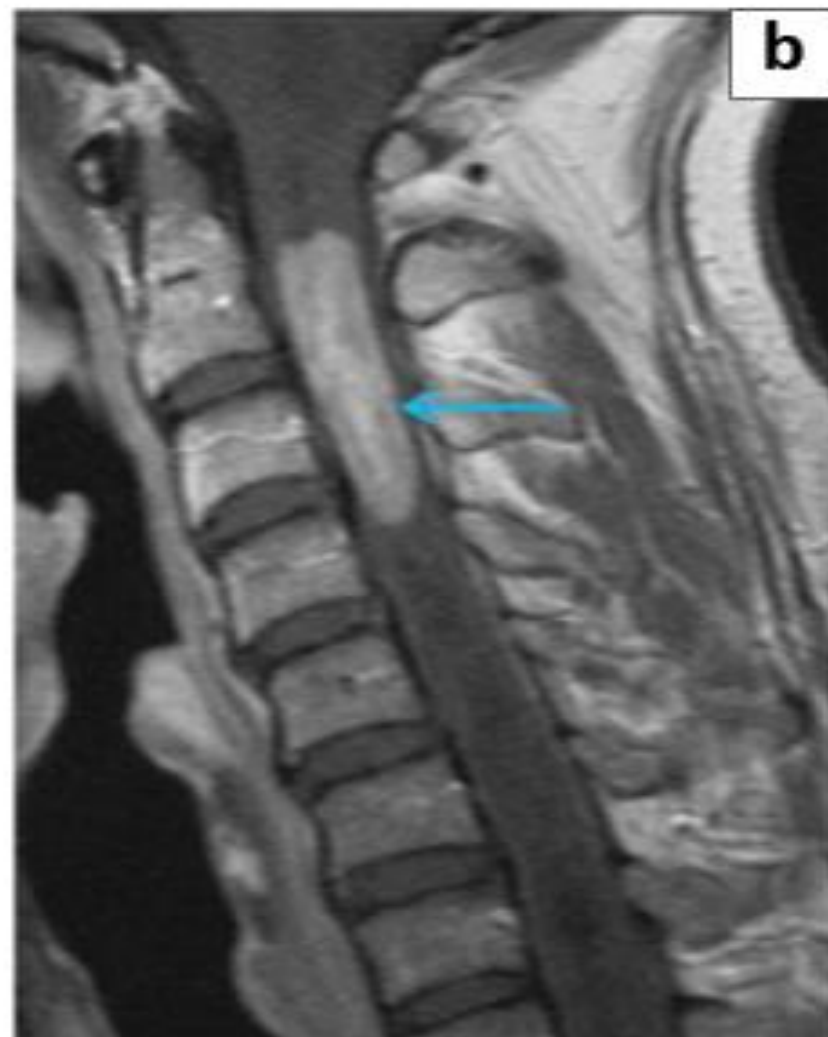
Intramedullary ependymoma in a 41-year-old man. (a) Sagittal T2-weighted image demonstrates a heterogeneous, well-circumscribed mass (white arrow) with extensive syringomyelia (yellow arrows); (b) Contrast-enhanced T1-weighted image demonstrates intense contrast enhancement of the tumour (blue arrow).
